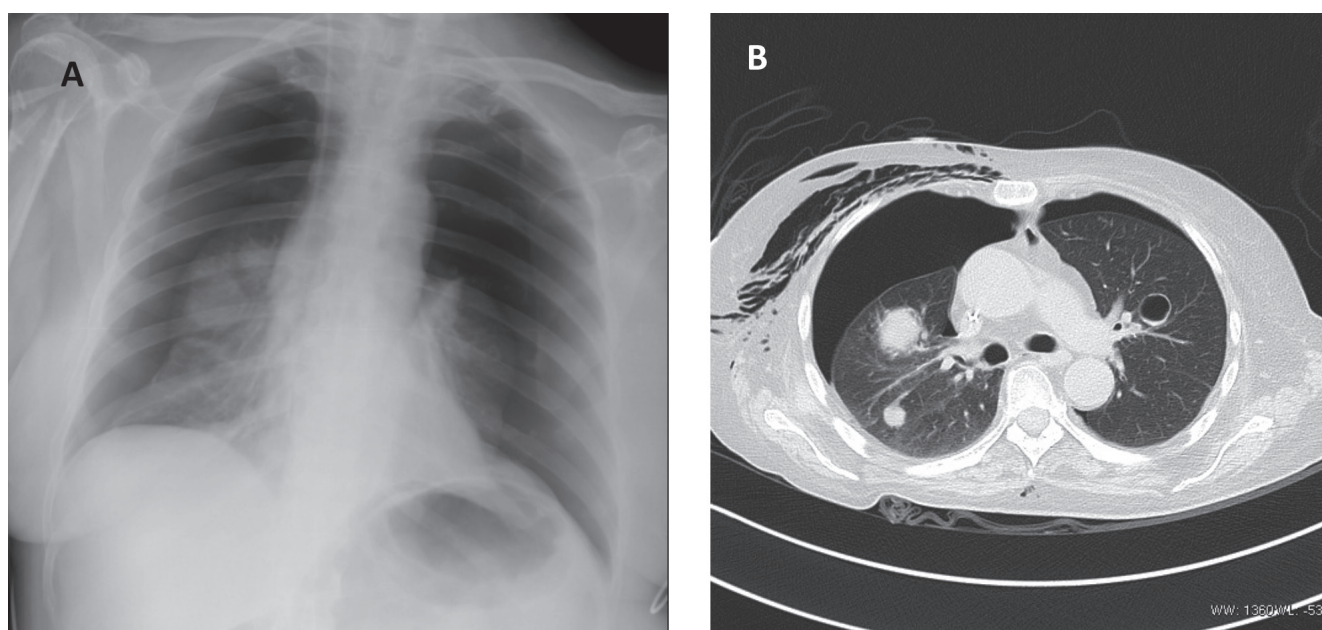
(A) Chest X-ray showing bilateral pneumothorax, and (B) computed tomographic scan showing bilateral pneumothorax and multiple lung lesions.
